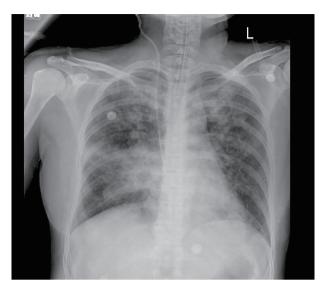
A chest radiograph showing ill-defined opacification over both lungs. Pulmonary edema, pneumonia or occult pathology are ruled out.
